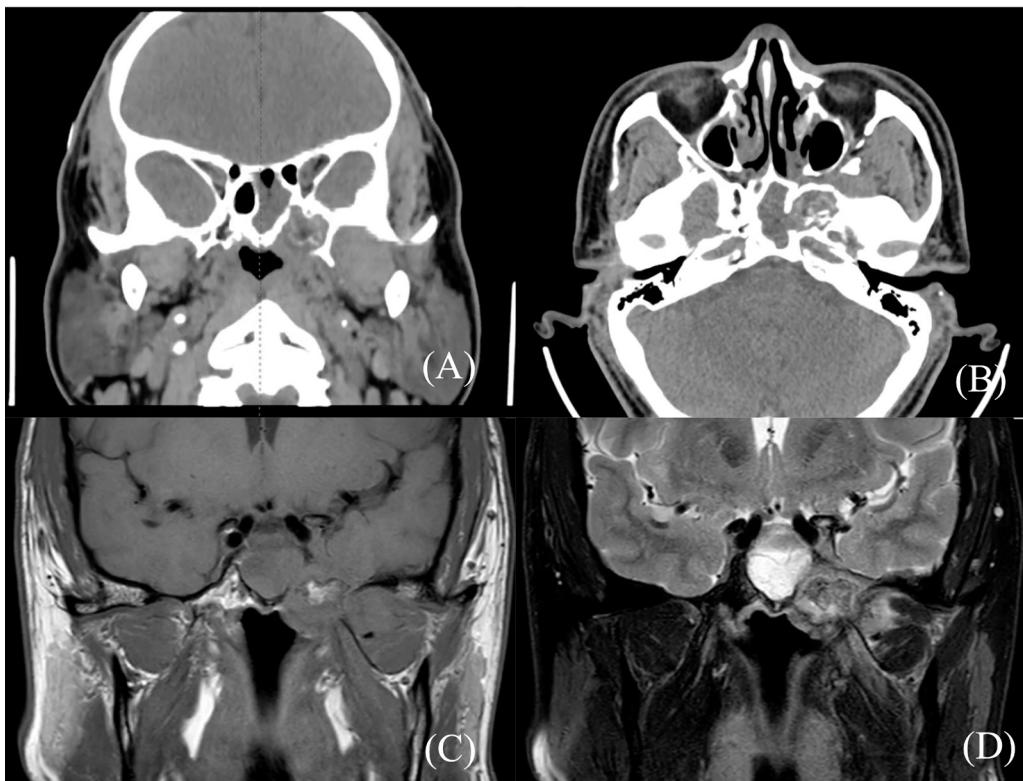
Computed Tomography scan showing opacification of the left sphenoid sinus with sclerotic bone change, a hypodense lesion with peripheral hyperdensity within the lateral recess of the sphenoid sinus (LRSS), and erosion of the greater wing of the sphenoid bone: coronal (A) and axial (B) views. Magnetic Resonance Imaging reveals a hypointense lesion within the left sphenoid sinus and lateral recess on a T1-weighted image (C), and a hyperintense lesion within the left sphenoid sinus together with a hypointense lesion within the left LRSS (D).
